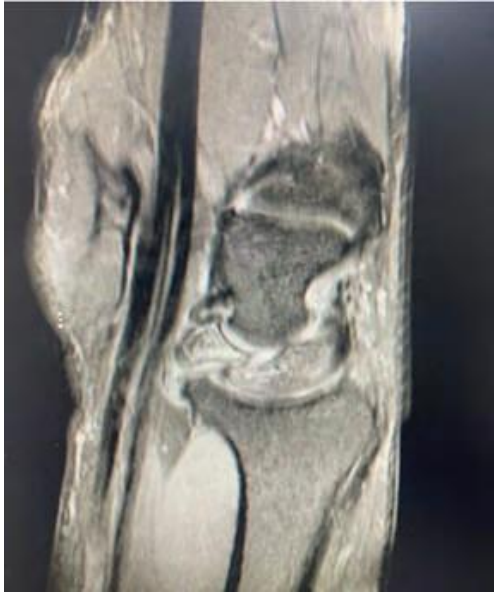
Sagittal cut magnetic resonance imaging scans taken prior to the surgical intervention of the right wrist showing fracture line over the lunate.
